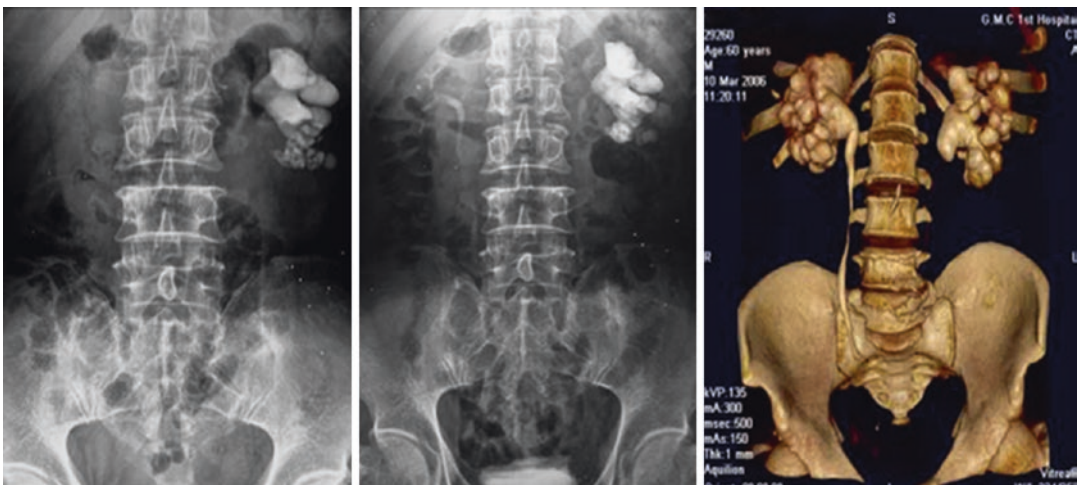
The KUB, IVU, and 3D CT reconstruction of renal collecting system and stones
